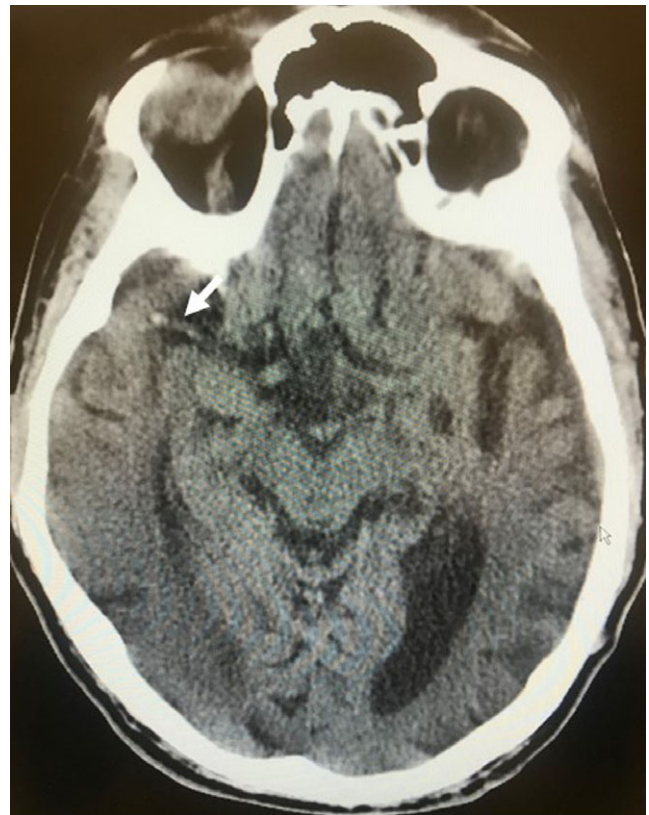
MSU CT image with no contraindications against thrombolysis and revealing a hyperdense artery sign of the right middle cerebral artery (arrow)[Colour figure can be viewed at wileyonlinelibrary.com]
